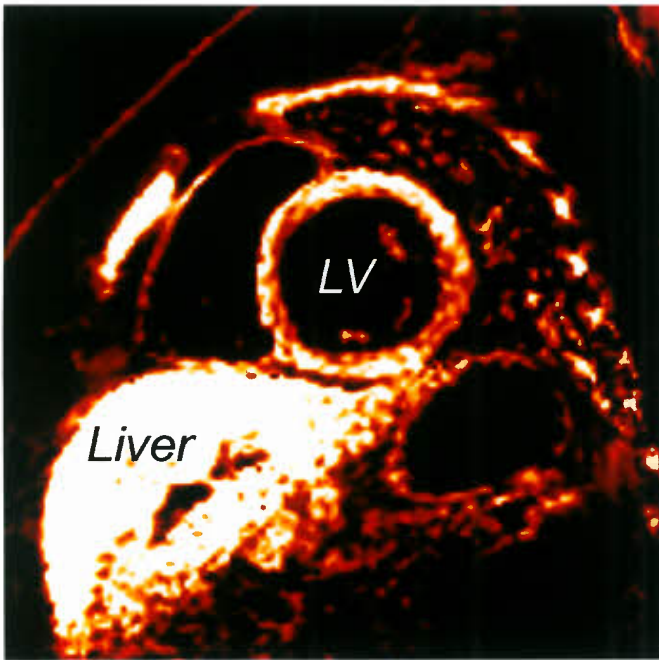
MRI assessment of myocardial and liver iron using T2* mapping in a patient with thalassemia major. Note the high signal intensity in the liver and in the left ventricular myocardium, corresponding to high iron concentrations in these organs.
